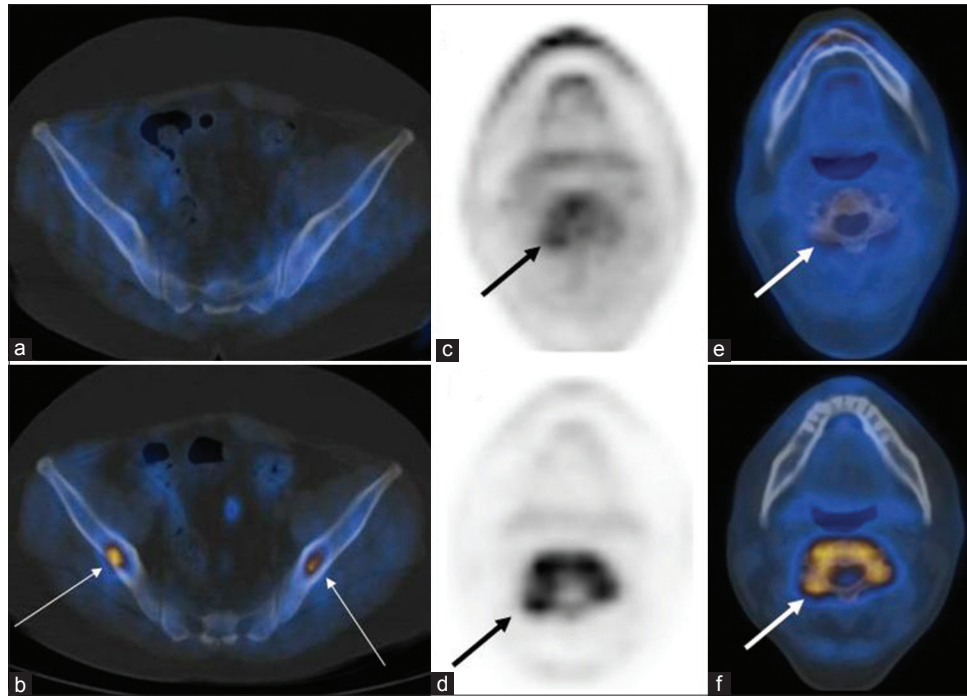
Transaxial fused FDG PET/CT image of the pelvis shows no abnormal uptake (a), whereas the corresponding ¹¹C-methionine scan (b) shows focal increased uptake in both iliac bones (thin arrows). Transaxial FDG PET (c) and fused PET/CT (e) image at C3 vertebra shows a hypermetabolic lesion (thick arrows). Corresponding ¹¹C-methionine image (d and f) shows more intense uptake with evidence of encasement of the thecal sac (thick arrows). CT = Computed tomography, FDG = Fluorodeoxyglucose, PET = Positron emission tomography
